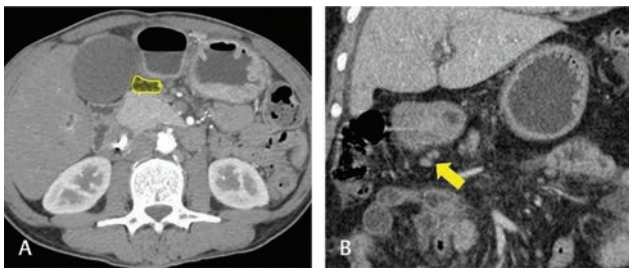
Station 6. Axial CT (A) shows the region of station 6 nodes along first branch and proximal part of right gastroepiploic artery (yellow area in A). Coronal reformatted CT (B) in venous phase shows few prominent infrapyloric nodes (arrow in B). CT, computed tomography.
